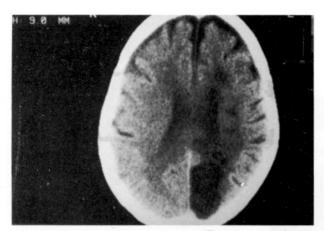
Cranial CT showed a hypodense well-circumscribed lesion at the left occipital region.
